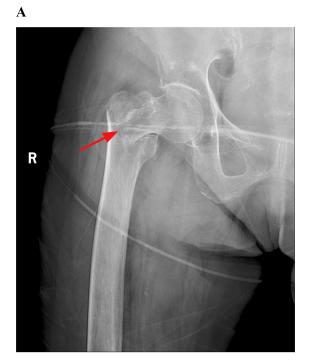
Representative X-ray images of a patient with an intertrochanteric fracture. (A) The X-ray image before surgery. The red arrow indicates a fracture site. (B) The X-ray image after surgery. R, right.
